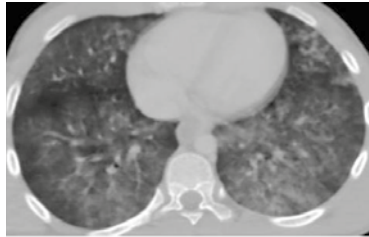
14-year-old male patient. In the axial CT image obtained in the parenchymal window, widespread increased alveolar density and diffuse pulmonary edema in both lungs are observed.
